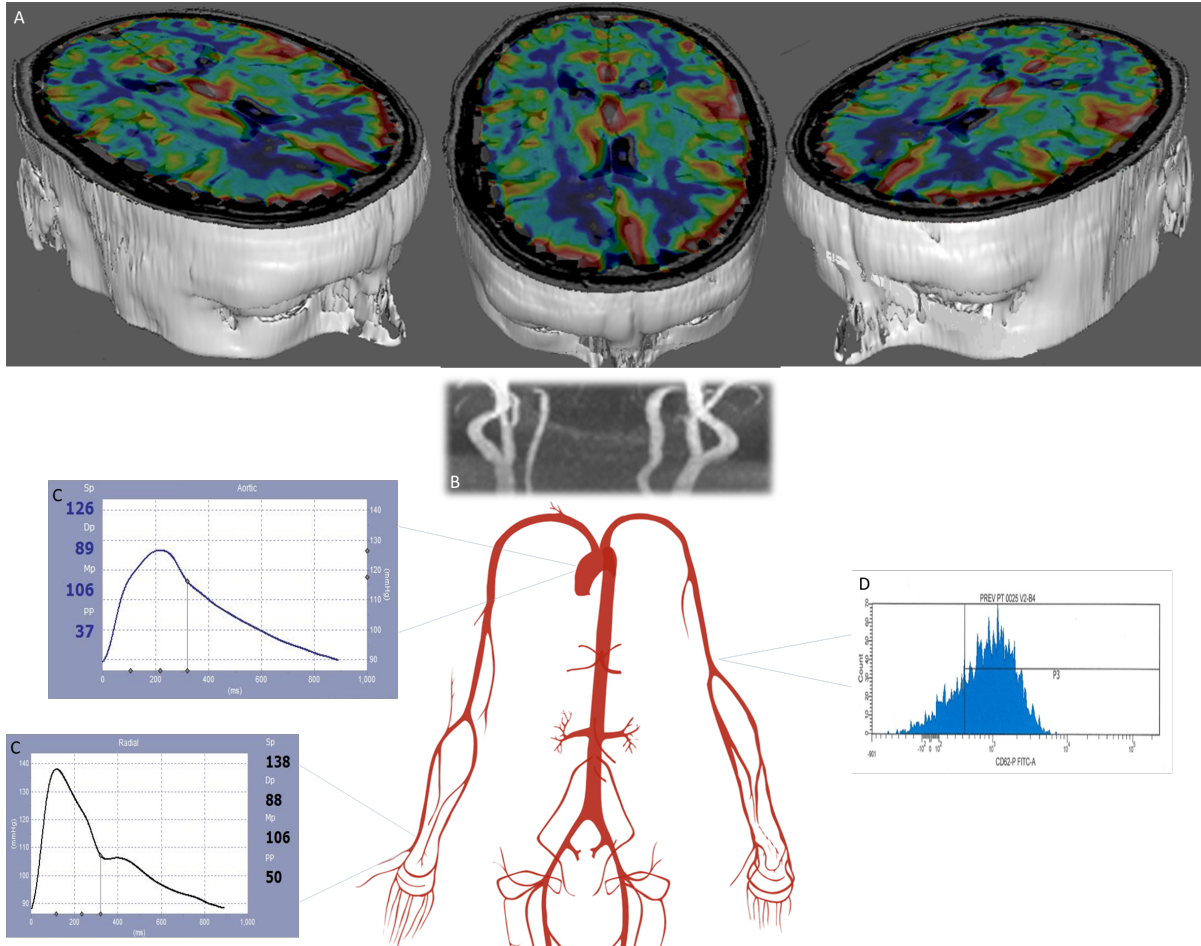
Mechanistic endpoints ('intermediary outcomes') assessing brain and systemic vascular function in response to cilostazol and isosorbide mononitrate. A) Brain – CVR MRI scans. The dark blue areas indicate the least reactive tissues, the bright red areas are the most reactive tissues. B) Carotid and vertebral arteries – phase contrast MRI scan, which also measures intracranial arterial, venous sinus and CSF flow. C) Systemic arteries -Aortic and Radial artery pressure waveforms and pulse wave velocity. D) Platelet function is assessed with P-Selectin flow cytometry.
